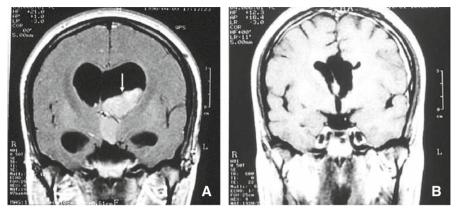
Neurocytoma (MRI) of the lateral ventricle extending to the III ventricle (*arrow*). A pre-operative. B post-operative
